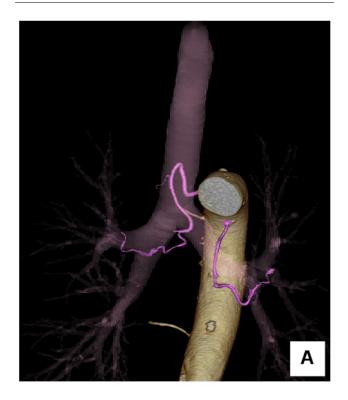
3D-reconstructed image of contrast-enhanced CT shows an enlarged intercostobronchial trunk and left bronchial artery at an ordinary location.
